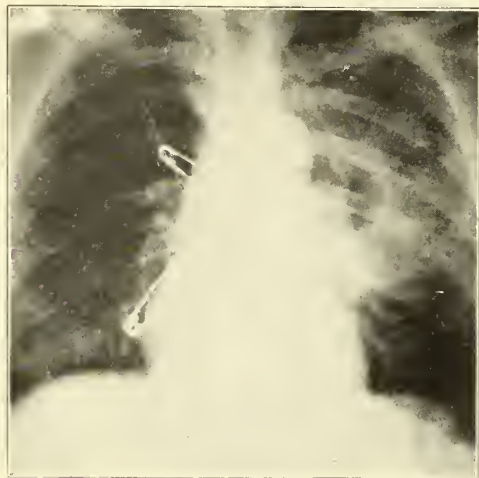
X-Ray, 50128—Abscess of Left Lung, October 22, 1924
